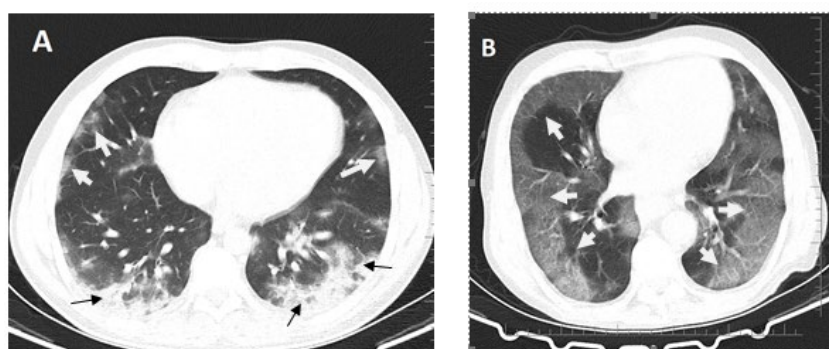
A: 28-year-old male patient with complaints of nausea and vomiting for 10 days, fever and cough for the last three days. Non-contrast enhanced chest CT showed multiple peripheral patchy ground glass opacities in bilateral multiple lobular and subsegmental with obscure boundary (white arrows). In addition, areas of consolidation in the bilateral lower lobes were observed on the CT scan (black arrows). B: A 79-year-old male patient is admitted to the emergency room with fever and cough. The patient whose PCR test was positive, showed multiple peripheral patchy view glass opacities (white arrows) in the thorax CT examination. (28)
